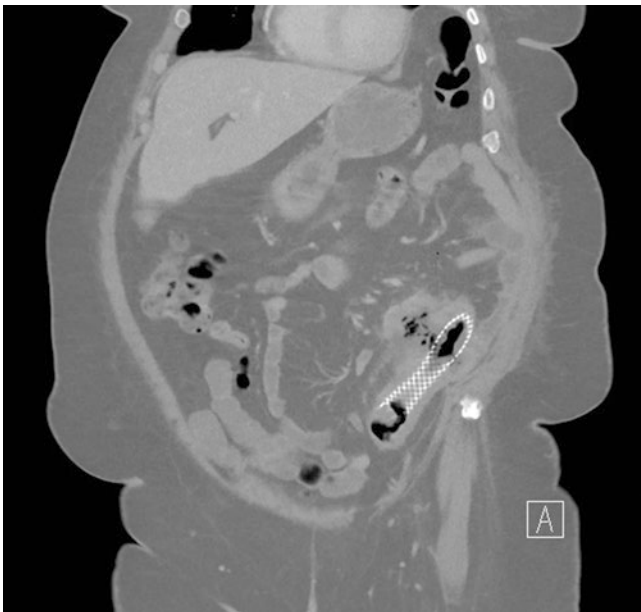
Coronal CT scan image showing a left-sided stent with evidence of perforation. (Courtesy of Daniel L. Feingold, MD)
